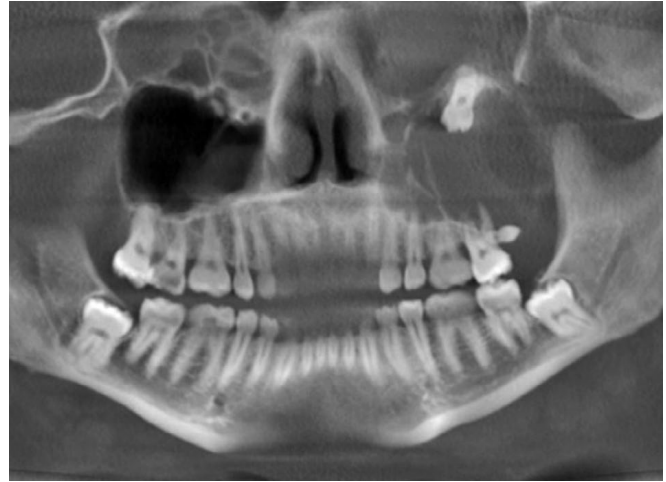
Cone beam panoramic radiograph showing opaque left antrum secondary to a dentigerous cyst displacing the maxillary left third molar just below the orbit. A supernumerary tooth can be seen posterior to the maxillary second molar.
